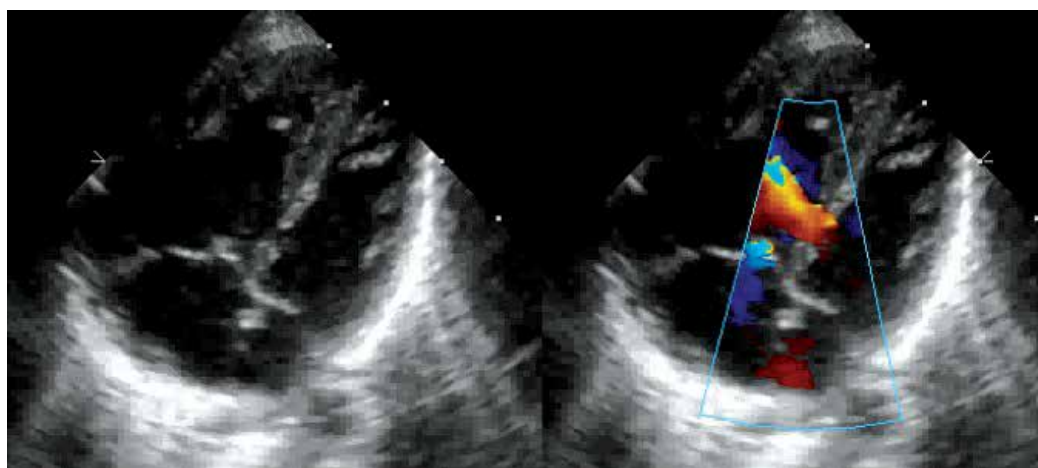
Echocardiographic apical four-chamber image demonstrating a ventricular septal defect (turbulent flow with aliasing).
